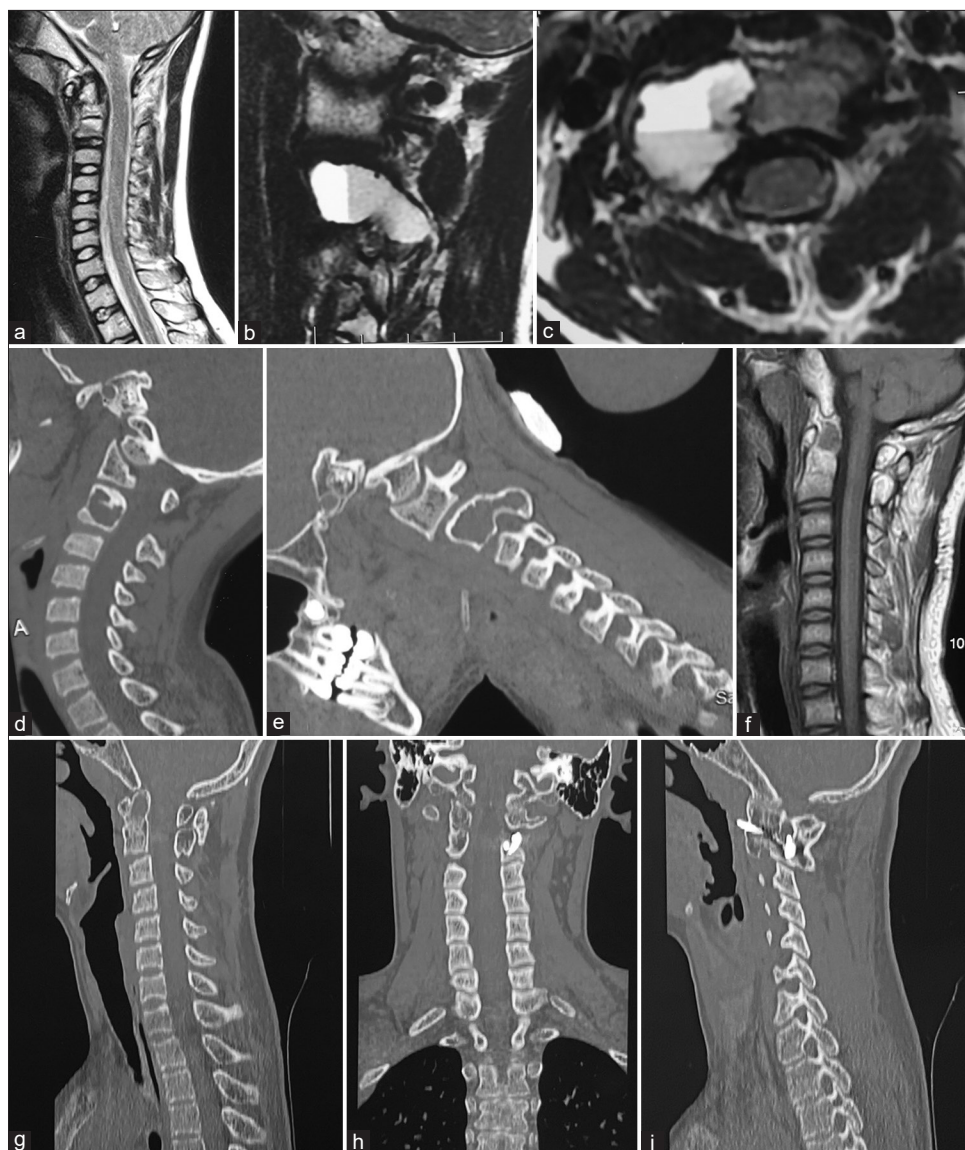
Images of an 11-year-old male child. (a) T2 weighted sagittal MRI image showing a lesion in the body of C2 with associated odontoid fracture and atlantoaxial instability, (b) Sagittal image of MRI through the facets showing a lesion involving the pedicles and facets of C2. Fluid level within the cyst content of the tumor is seen, (c) Axial image of MRI showing the lesion with multiple fluid-fluid levels, (d) Sagittal image of CT scan showing the lytic lesion involving the C2 body and facet on one side, (e) Sagittal cut of CT scan through the facets showing the lytic lesion involving the region of C2 body-facet, (f) Delayed Postoperative MRI image showing excision of the tumor with the healing of the odontoid fracture and craniovertebral re-alignment, (g) Sagittal cut of CT through the healed odontoid fracture with good bone fusion, (h) Coronal image of CT showing the unilateral fixation, (i) Sagittal image of CT with cuts passing through the facets showing the implant and bone fusion. CT - Computed tomography, MRI - Magnetic resonance imaging
